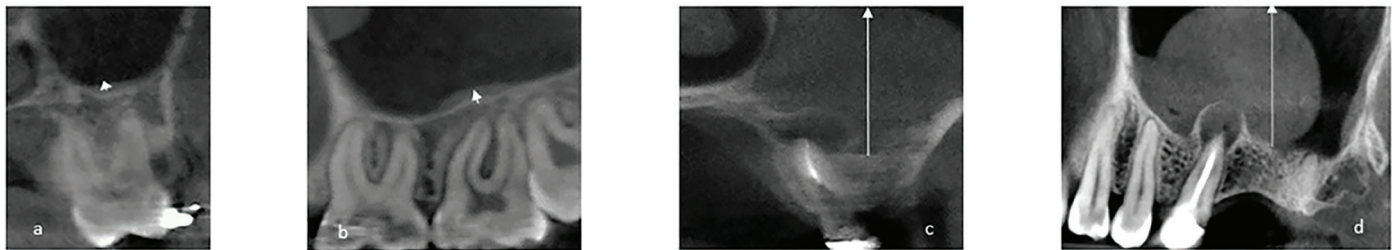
Radiographic demonstration of mucosal thickening measurements. a) Normal mucosal thickening coronal sections, b) normal mucosal thickening sagittal sections, c) pathologic mucosal thickening coronal sections, d) pathologic mucosal thickening coronal sections.
